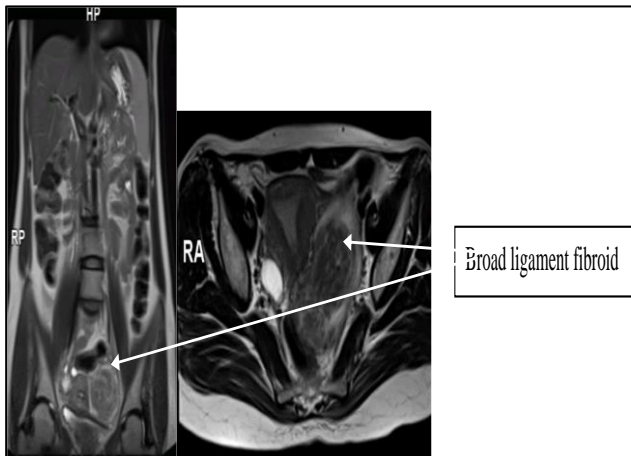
MRI images of fibroid.
